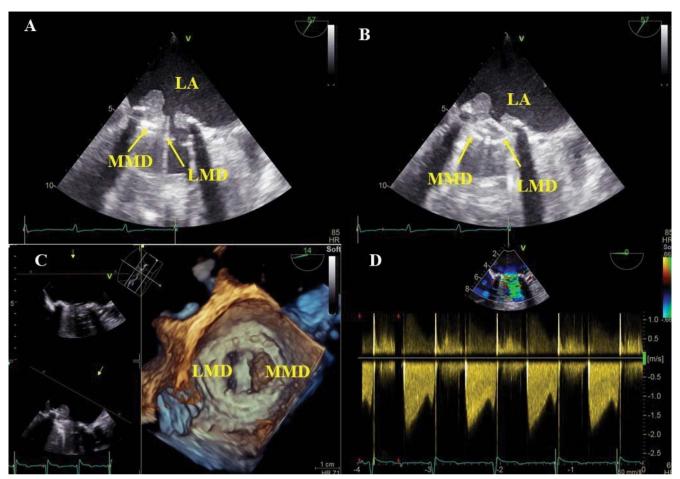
Transesophageal echocardiography evaluation of the mitral prosthesis. Bicommissural views (A- diastole, and B- systole) showing massive mitral prosthesis thrombosis with a blocked medial disc and incomplete closing of the lateral disc due to extensive thrombosis. C. 3D-TEE en-face view of the mitral prosthesis showing medial obstructed disc with an organized thrombus. D. Continuous wave Doppler interrogation of the mitral prosthesis demonstrating elevated transmitral gradients. LA, left atrium; LMD, lateral mitral disc; MMD, medial mitral disc.
